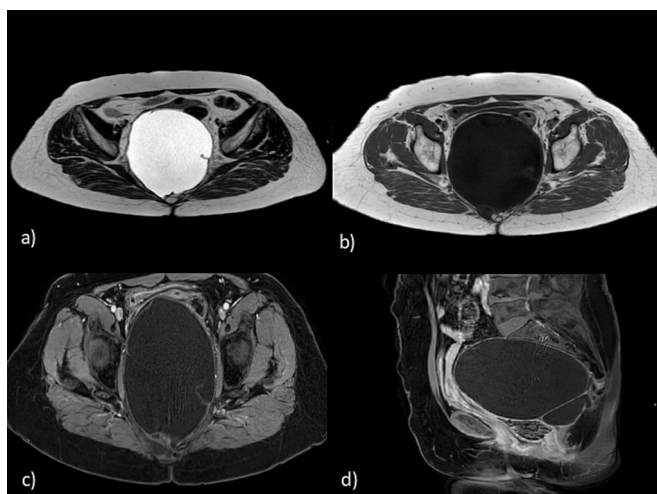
Displays a detailed view of the axial T1-weighted (a), axial T2-weighted images (b), T1-weighted axial contrasted (c), and sagittal contrasted (d) MRI images of TGC. The images provide a clear visualization of the structure and composition of TGC, allowing for a more comprehensive understanding of the subject.
